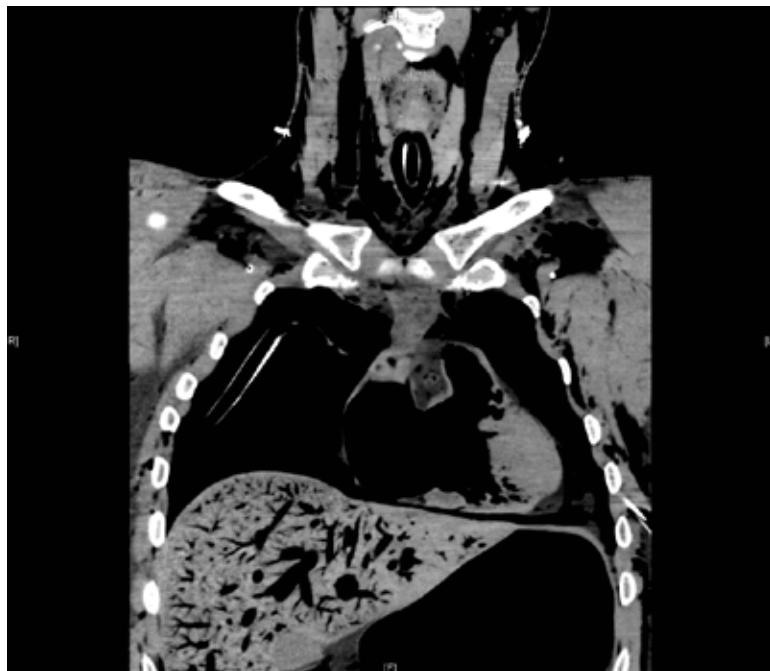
A postmortem imaging study (CT scan) on a diver who died of an air embolism shows extensive gas present in the heart and liver.
